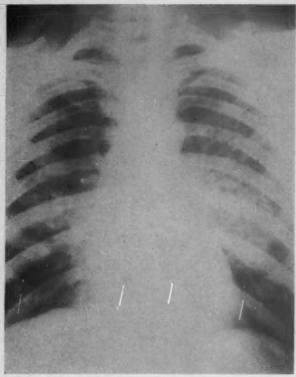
Case 22. X-ray film of the chest. Pulmonary edema of high altitude is observed in both lungs.
